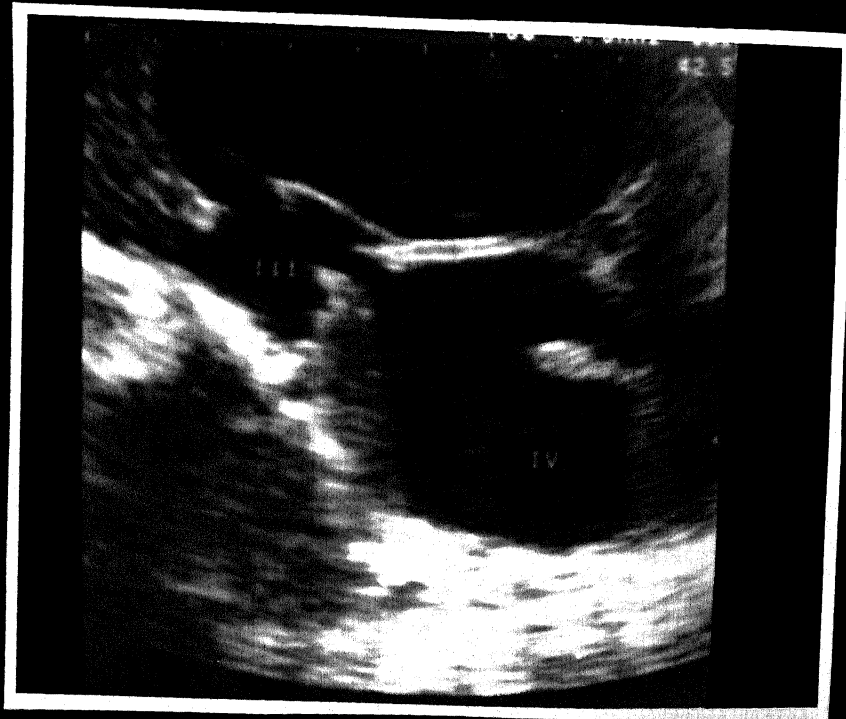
Sagittal sonogram showing dilatation of all four ventricles. Foramen of Monroe and Aqueduct of Sylvius are beautifully demonstrated.
